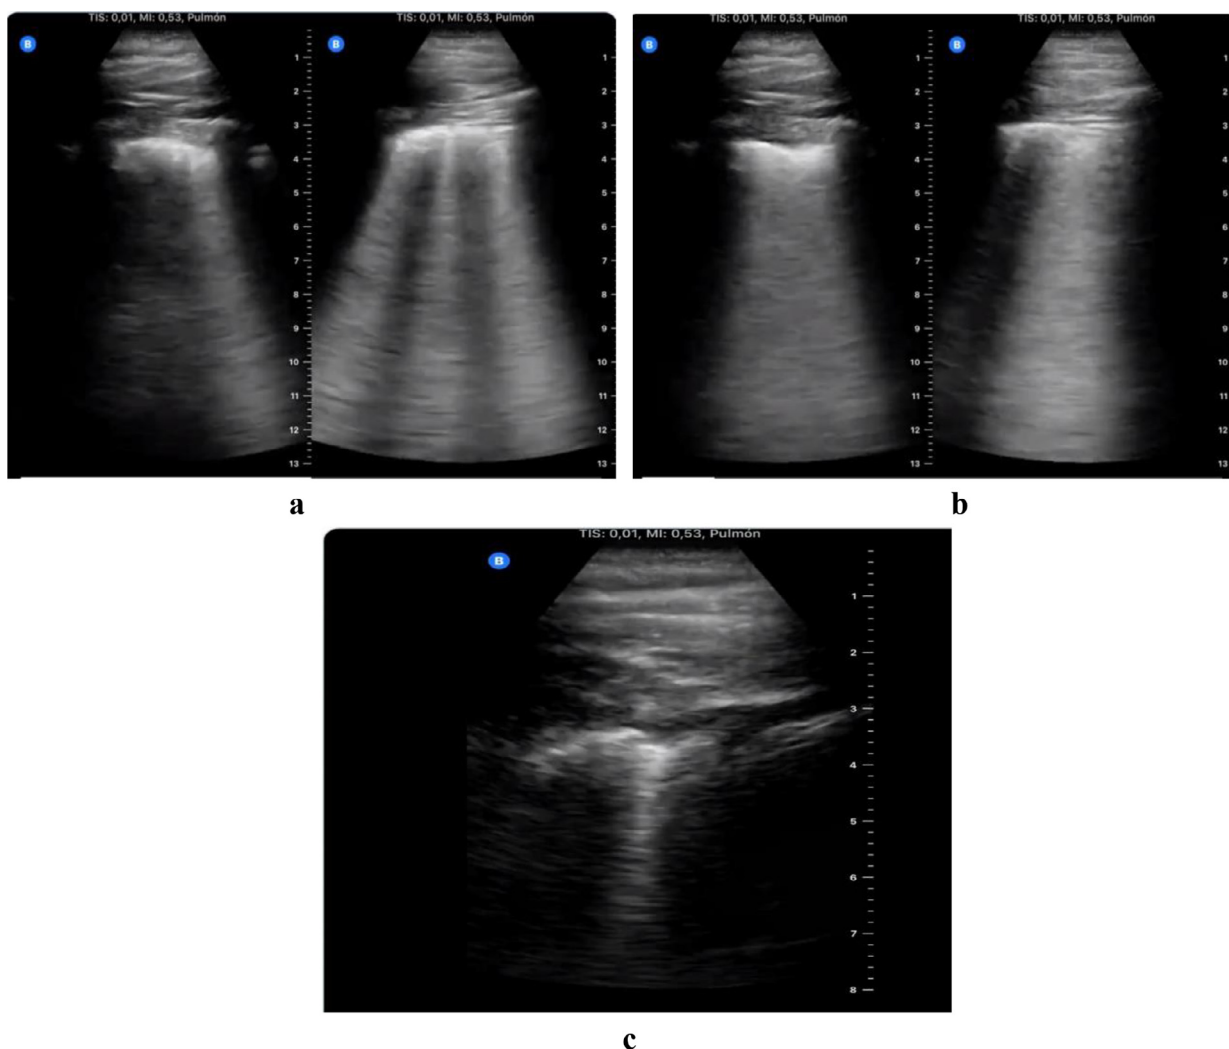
Serial lung ultrasound images from a 35-y-old emergency physician who tested positive for COVID-19. (a) Scattered B-lines in both lungs, with thickened pleural line, at an early stage of the disease. (b) Diffused B-lines (white-lung sign) with disease progression. (c) Subsequent subpleural consolidation in a later stage of the disease. Reprinted with permission from [Tung-Chen \(2020\)](#).
